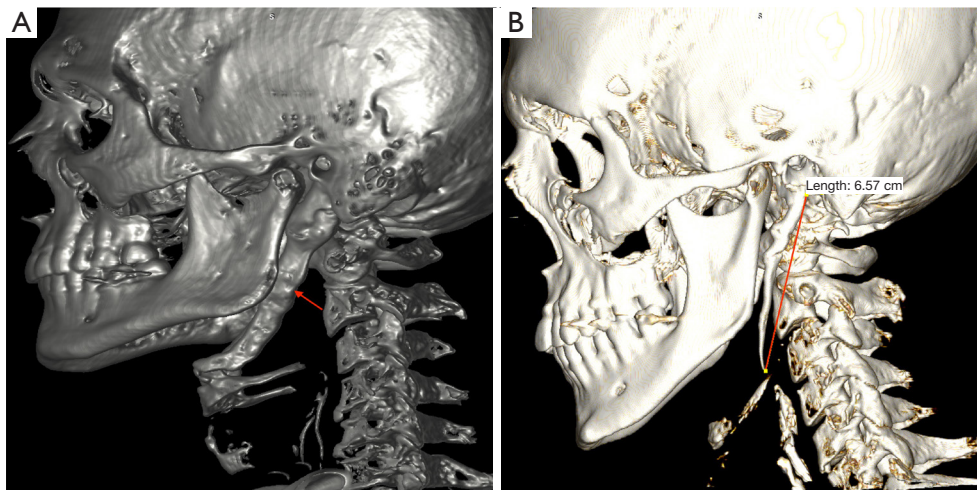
Three-dimensional CT reconstruction of patients with Eagle's syndrome. One with a calcified stylohyoid ligament indicated by the red arrow (A) and one with an elongated styloid process with a demonstrated measurement along the sagittal plane (B). CT, computed tomography.
